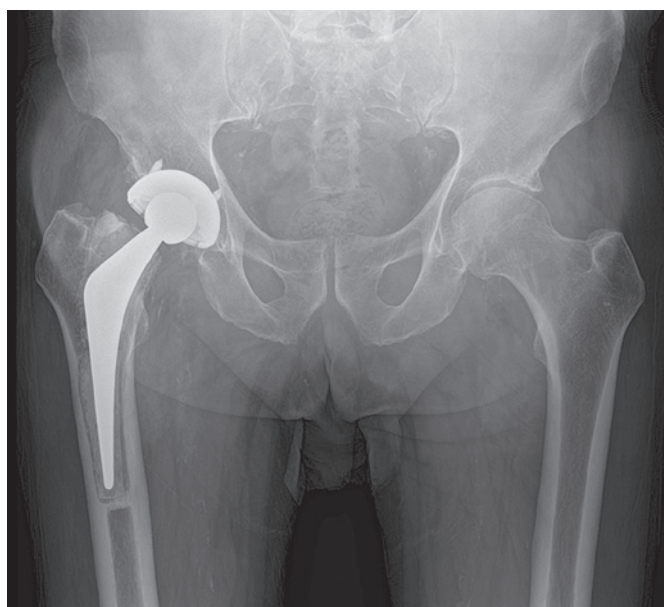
Radiographic imaging of a loose THA in anteroposterior view (patient No. 25). *Coagulase-negative Staphylococcus* was detected exclusively through PCR.
